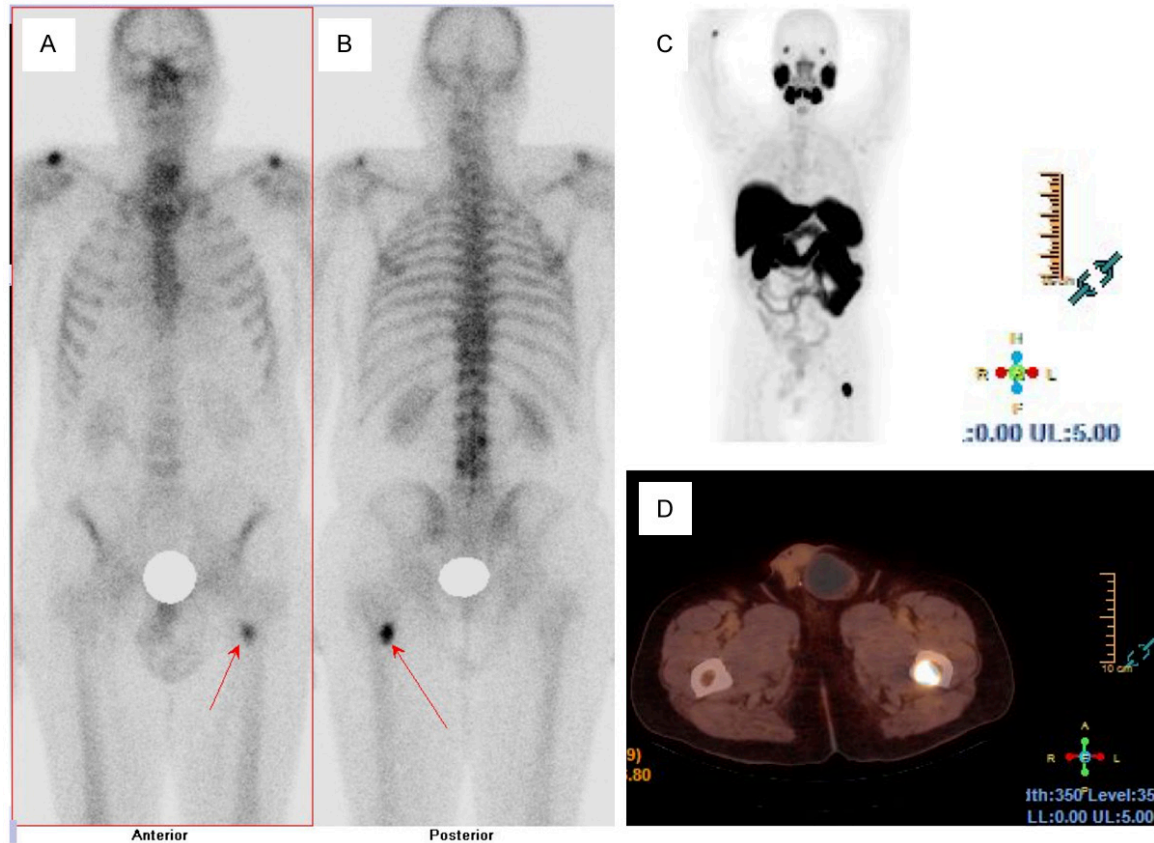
^{18}F -PSMA-1007 PET/CT and bone scintigraphy of a 67 years old patient after radical prostatectomy and radiation therapy of the prostate bed six years ago. The PSA level at the time of the study was 4.35 ng/ml. A and B. A pathological $^{99\text{m}}\text{Tc}$ uptake (arrows) in the proximal left femur on bone scintigraphy. C and D. The corresponding pathological ^{18}F -PSMA uptake in PET/CT.
